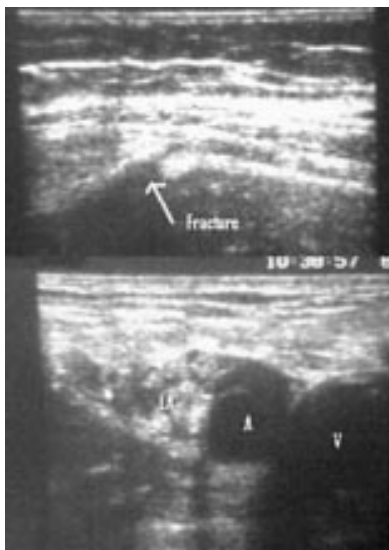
Sonograms demonstrating distal femoral fracture (top); and outlining femoral vein (V), femoral artery (A), and demonstrating introduction of local anaesthetic (LA) around femoral nerve (below).
